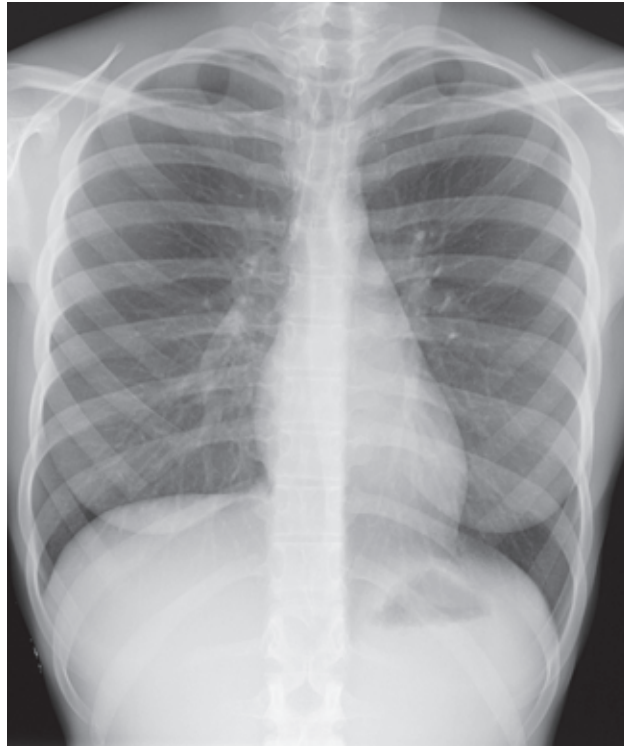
Chest x-ray (normal). Normal chest x-ray shows white bones and dark lung fields. The heart (*center of image*) and organs below the diaphragm (*bottom third of image*) are also white because of the density of the soft tissue through which the x-rays pass.
